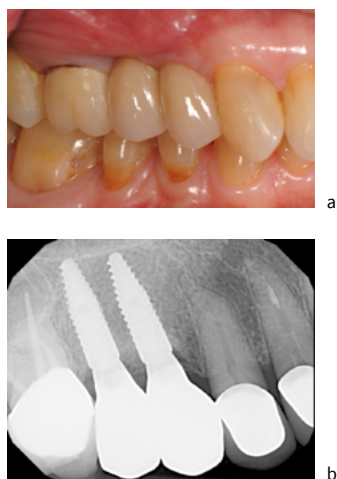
Adjacent reduced-diameter platform-switched implants ~2mm apart for edentulous space management and restorative planning. a: Clinical view showing good esthetics and contours. b: Radiograph showing good maintenance of crestal bone height
